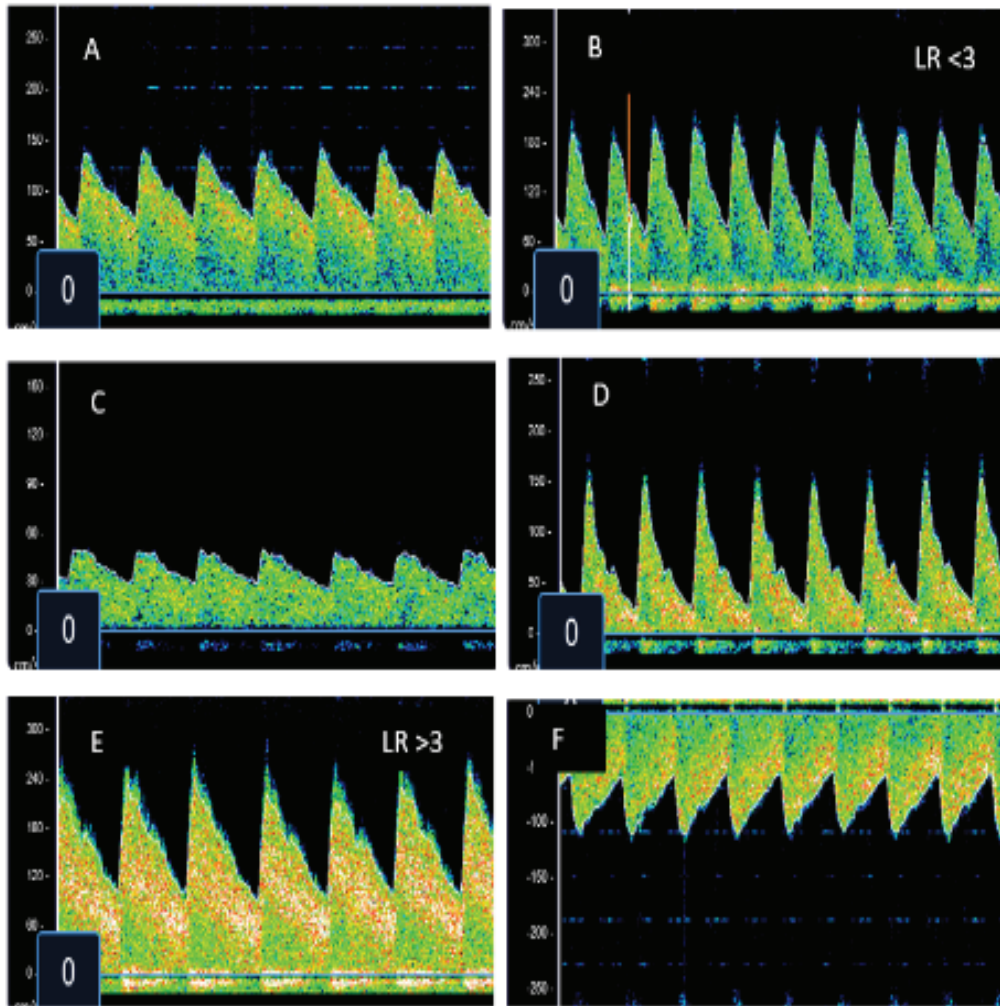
A. Normal middle cerebral artery (MCA) transcranial Doppler ultrasound (TCD) flow velocities and waveform for a 3-year-old child. Peak= systolic, EDV= end diastolic velocity, PI= pulsatility index . TCD with normal systolic flow velocity, reduced diastolic flow velocity, increased pulsatility index. These findings represent a child categorized as having microvascular obstruction. C. TCD with increased systolic flow velocity, increased diastolic flow velocity, loss of dichrotic notch. Lindegaard ratio (LR) <3. These findings represent a child categorized as having hyperemia. D. TCD with increased systolic flow velocity, increased diastolic flow velocity, presence of dichrotic notch. LR >3. These findings represent a child categorized as having cerebral vasospasm. E. TCD with decreased systolic flow velocity, decreased diastolic flow velocity, decreased mean flow velocity. These findings represent a child categorized as having low flow. F. TCD with increased systolic flow velocity, increased diastolic flow velocity, increased mean flow velocity in the basilar artery. At the same time, all measurements in the middle cerebral arteries were normal. These findings represent a child categorized as having isolated posterior hyperemia.
